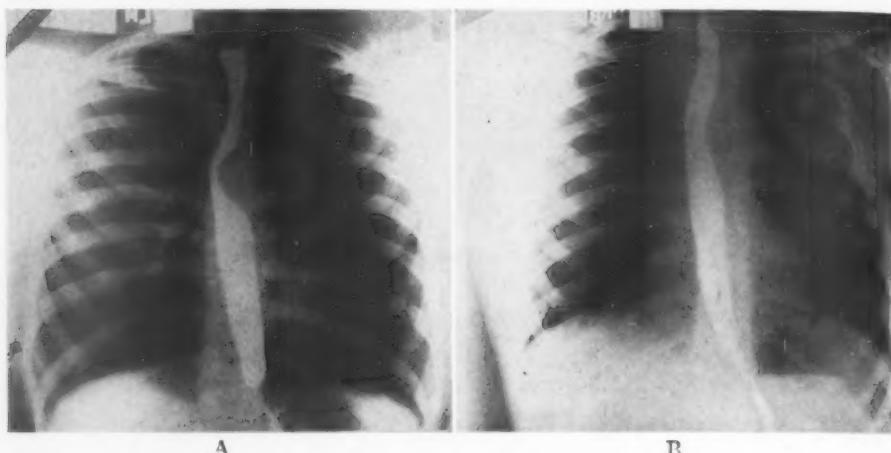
Roentgenograms of the chest during barium swallow. The heart size is considered normal; it is perhaps slightly more globular in shape than is usually seen. On these and other films there is questionable evidence of slight left ventricular enlargement. Notching of the ribs is seen. A. Preoperative roentgenogram. There is marked indentation upon the esophagus by the aneurysmal mass. B. Roentgenogram taken on 12th postoperative day. The circular indentation of the esophagus seen in the preoperative film is not evident.
